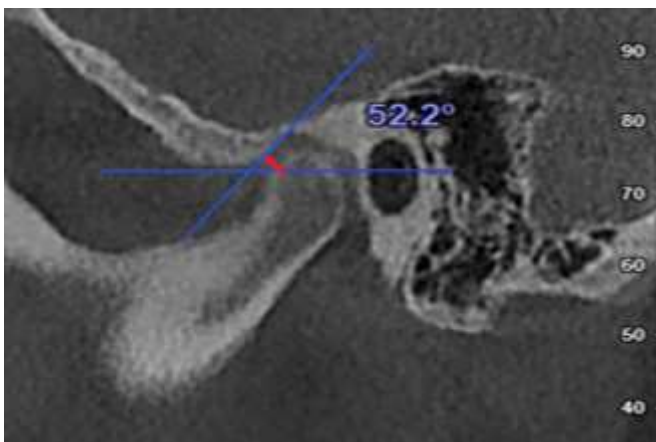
CBCT showed the measurements of articular eminence inclination (Best-fit line method).
